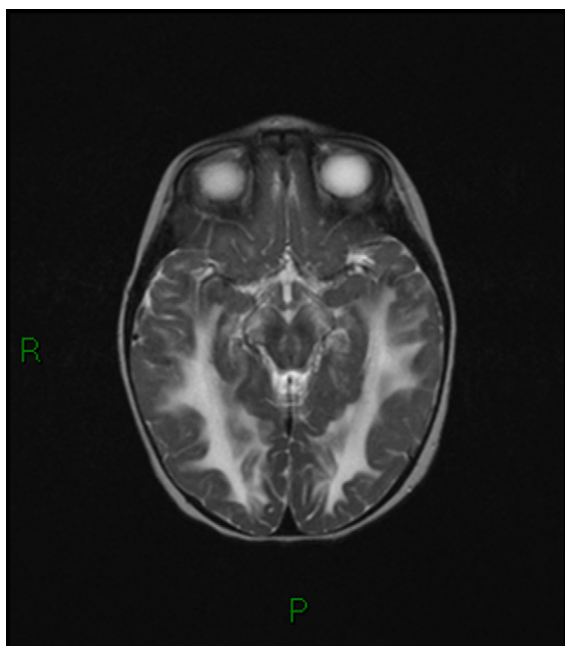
T2-weighted image of the brain showing extensive white matter alteration, without sparing of the u-fibers. Signal alterations at the level of brain stem resembles what we dubbed “inversed giant panda face”.
